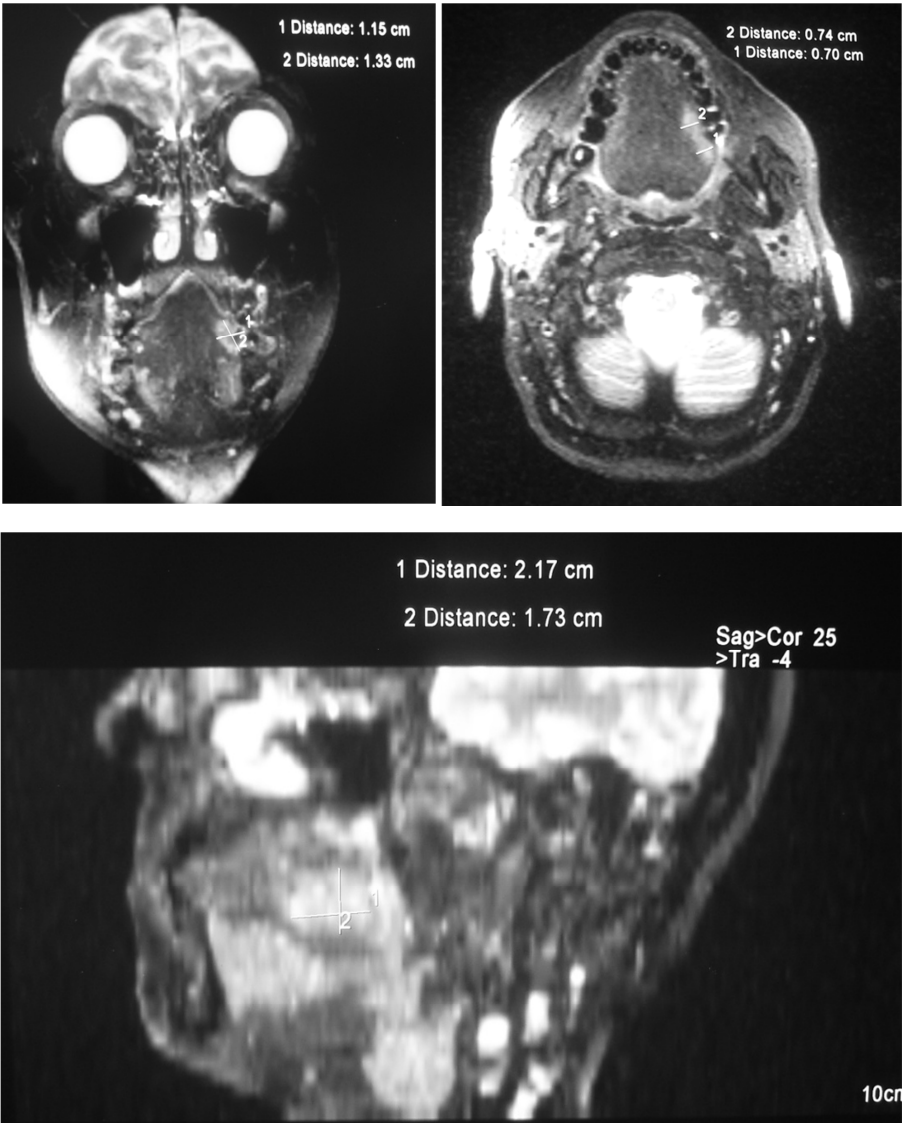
An example of the measured distances in various MRI sections (coronal, horizontal and sagital). Note the difference in image quality between the reconstructed sagital image and the other two, which accounts for the difficulty in MRI measurement of tumor’s depth.
